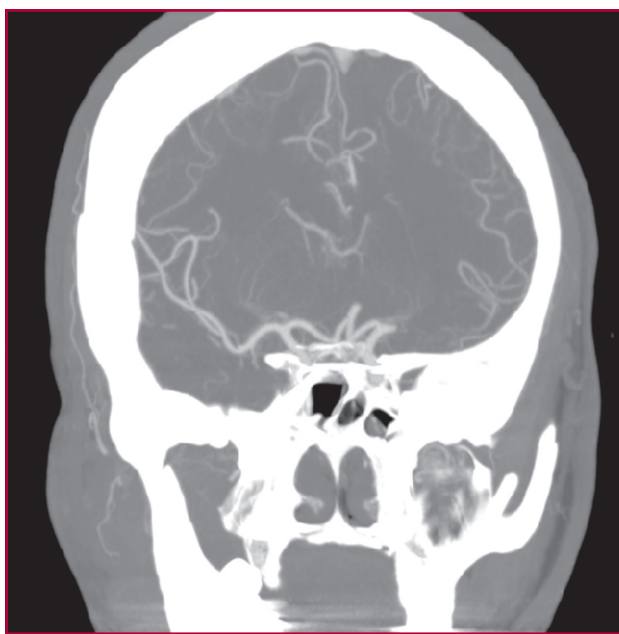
Baseline CT-angiography (coronal view) showing complete occlusion of the M1 segment of the left medial cerebral artery.
